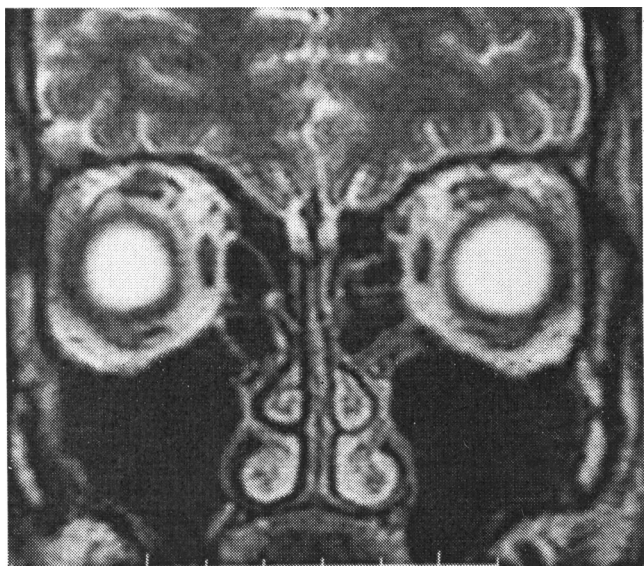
T2-weighted coronal image with decreased olfactory bulb volume and absence of damage in the frontal lobe area.
